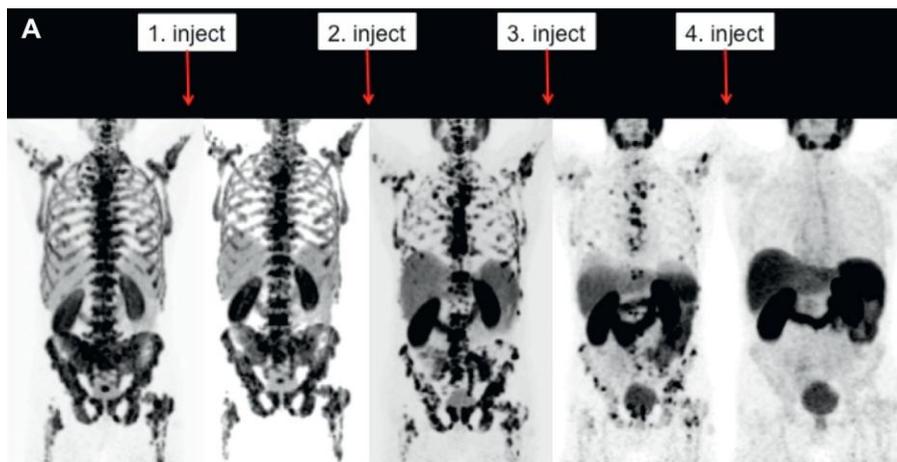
Complete remission in a 71-year-old patient after 4 cycles of ^{177}Lu -PSMA.⁹
